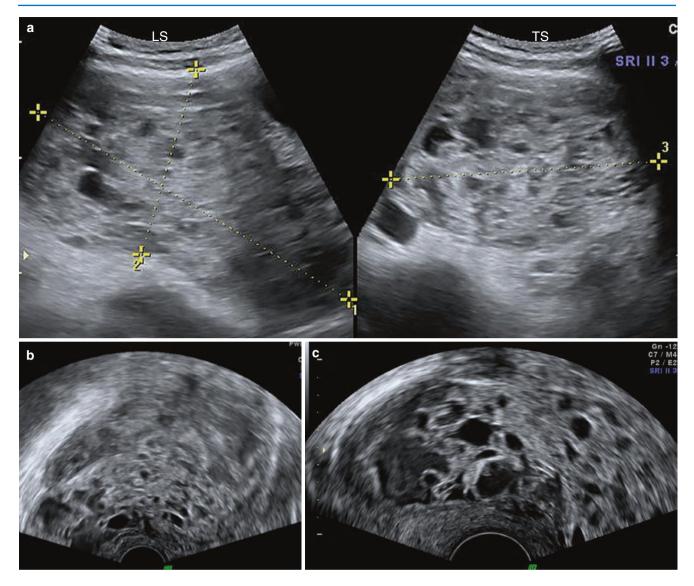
Molar pregnancy (complete mole). The patient was diagnosed to have an incomplete abortion elsewhere, for which evacuation was done. The patient continued to bleed, and beta hCG was reported to be more than 3,00,000 mIU/mL. (a) Image shows the uterus with the entire uterine cavity (including most of the cervical canal), seen filled with a heterogeneous mass with tiny cysts, giving it a snowstorm appearance. (b–d) The mass shows multiple small anechoic cystic spaces within (the vesicles). (e, f) Doppler shows colour flow signals in various directions, filling the spaces between the vesicles. Flow is seen with a PSV of 17.84 cm/s and RI of 0.34 (low-velocity, low-resistance flows)
